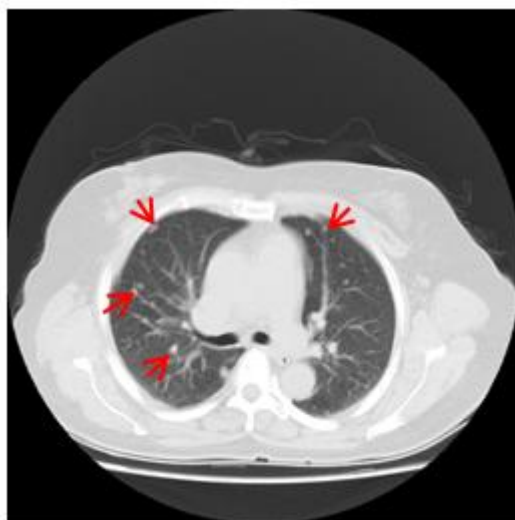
CT Findings Indicating Pulmonary Metastases
